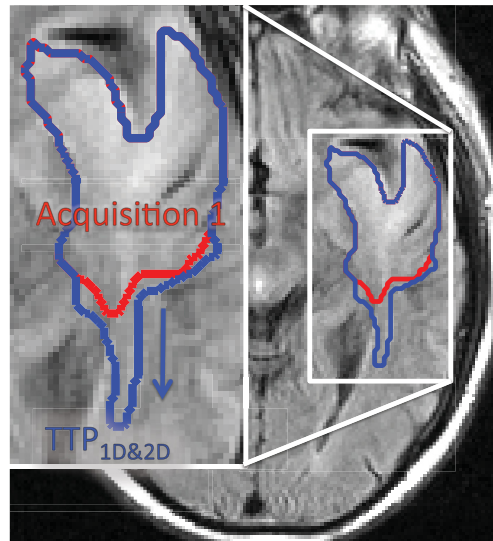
Patient 3 reached  $TTP_{1D}$  and  $TTP_{2D}$  at 396 days but did not reach  $TTP_{3D}$ . The red delineation is the first MRI scan and the blue delineation is the scan when  $TTP_{1D}$  and  $TTP_{2D}$  were reached. The large finger-like pattern resulted in the 1D RECIST and 2D RANO metrics being more sensitive than the 3D Volumetric metric.
